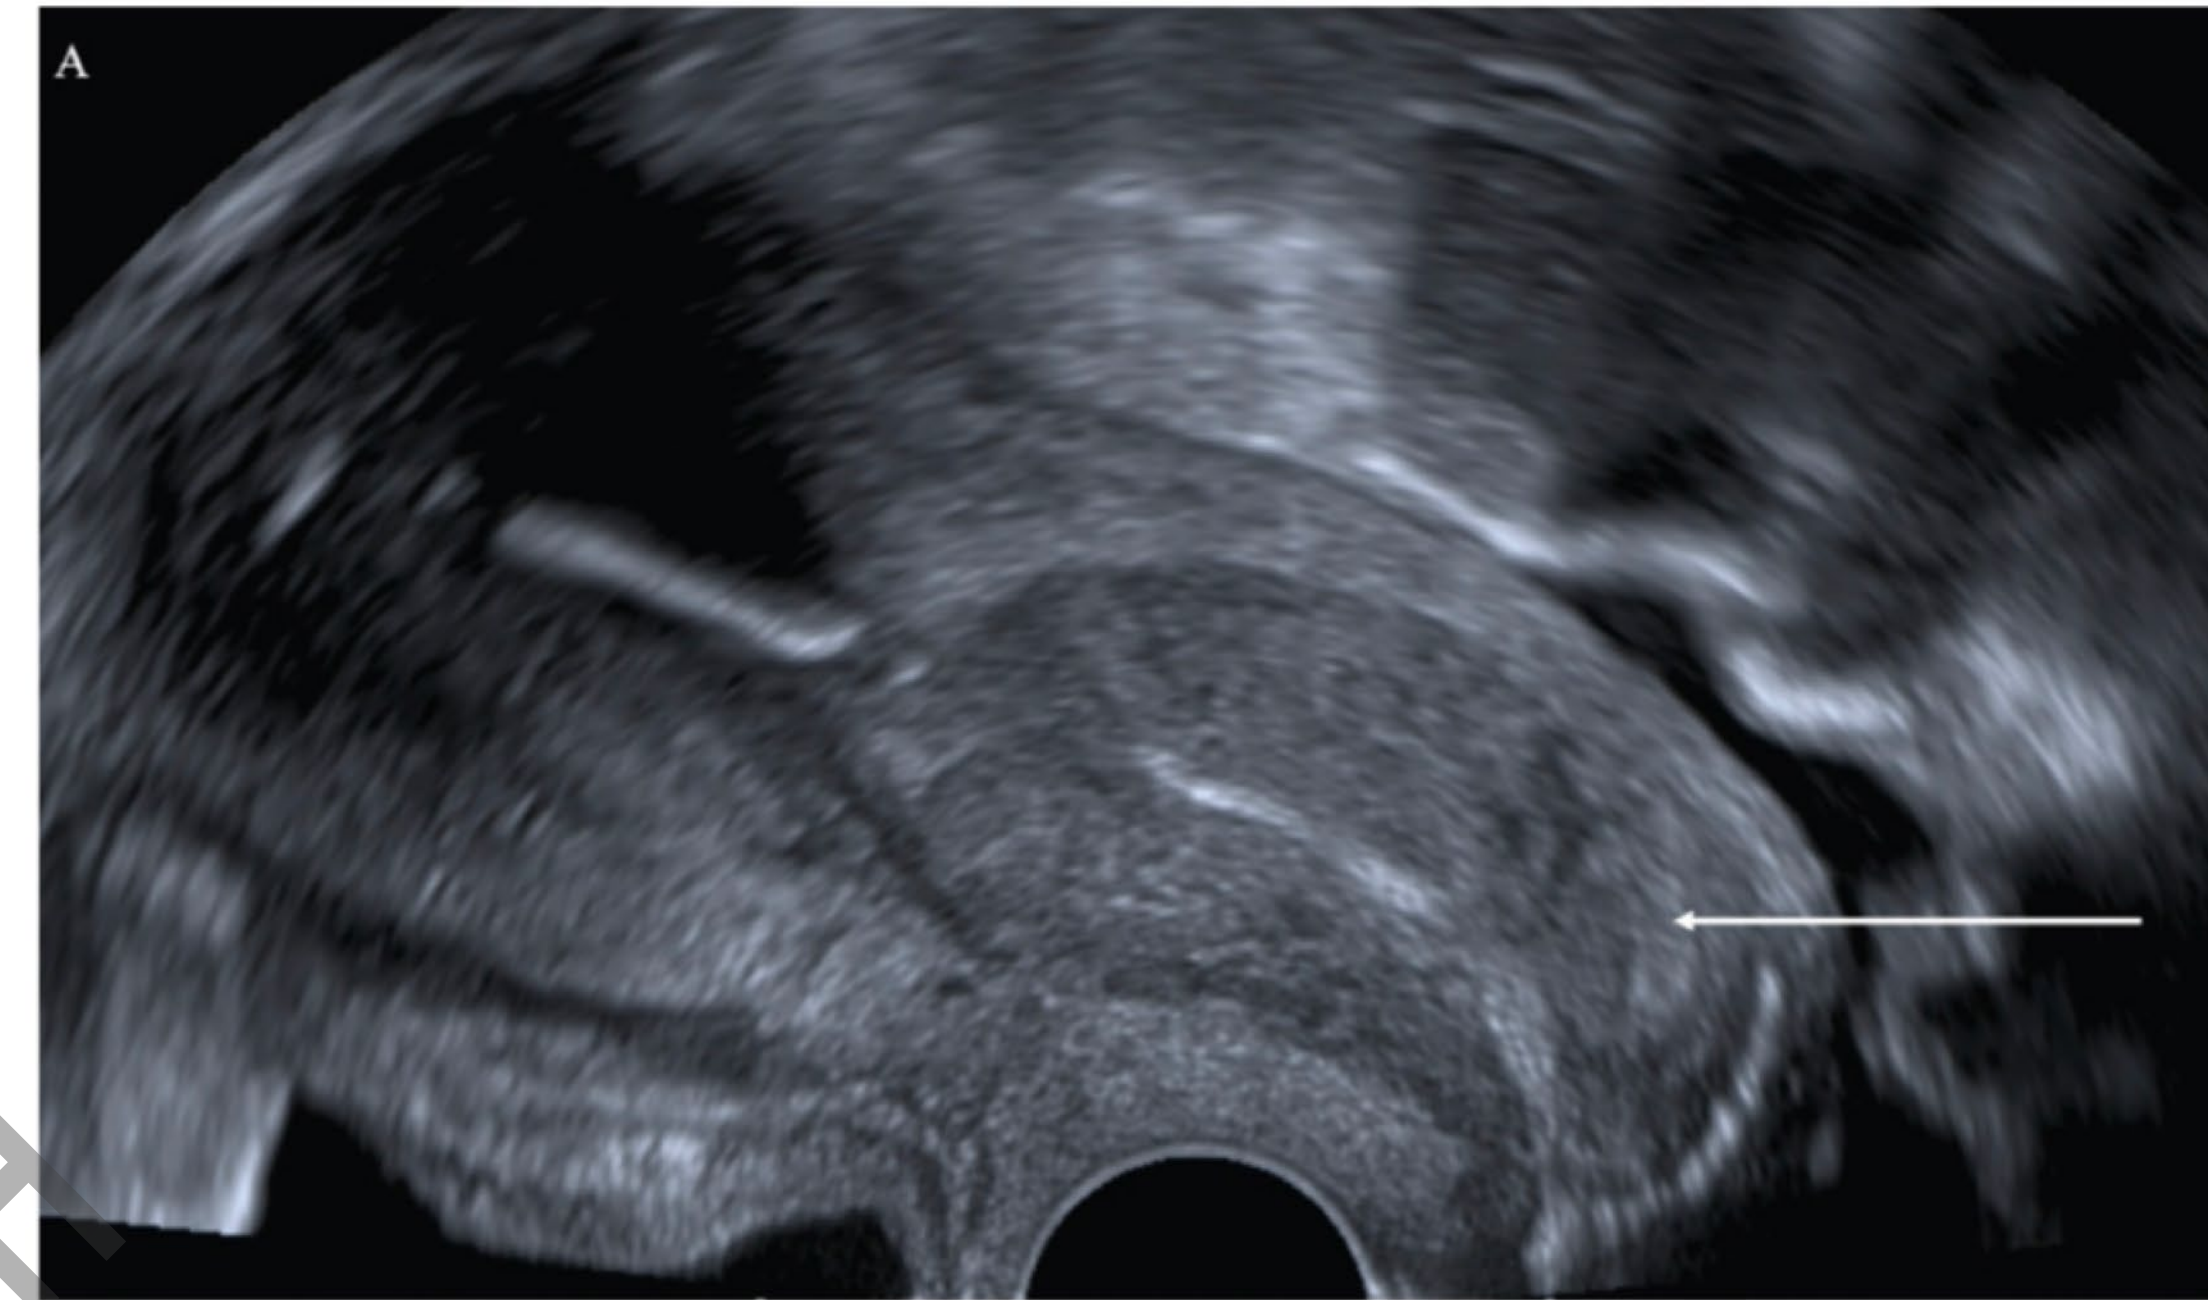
Transvaginal ultrasound showing the cervical mass.
